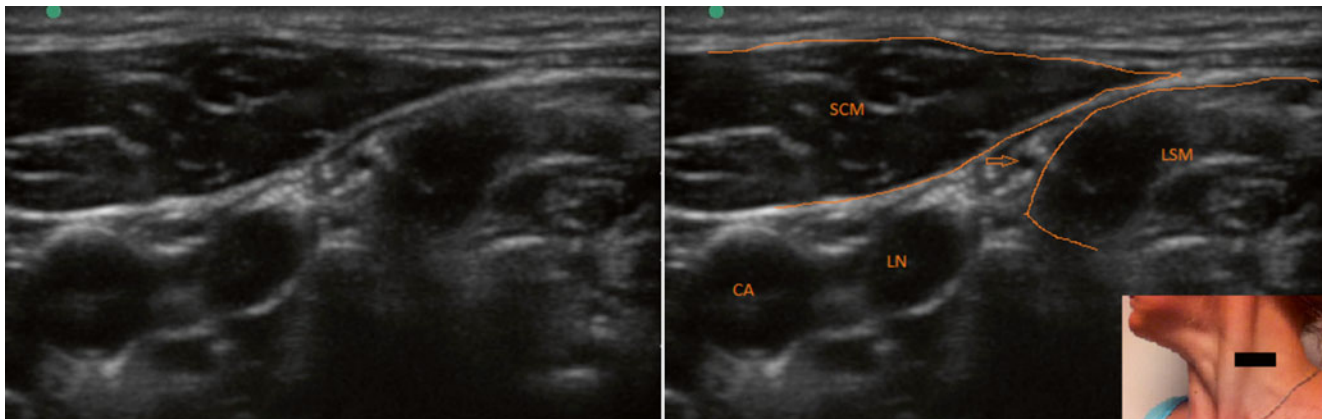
Ultrasound image of the spinal accessory nerve (marked by the *arrow*) at the posterior triangle. *SCM* sternocleidomastoid muscle, *LSM* levator scapulae muscle, *CA* carotid artery, *LN* lymph node. Internal jugular vein is compressed (Image courtesy of Agnes Stogicza, MD)
